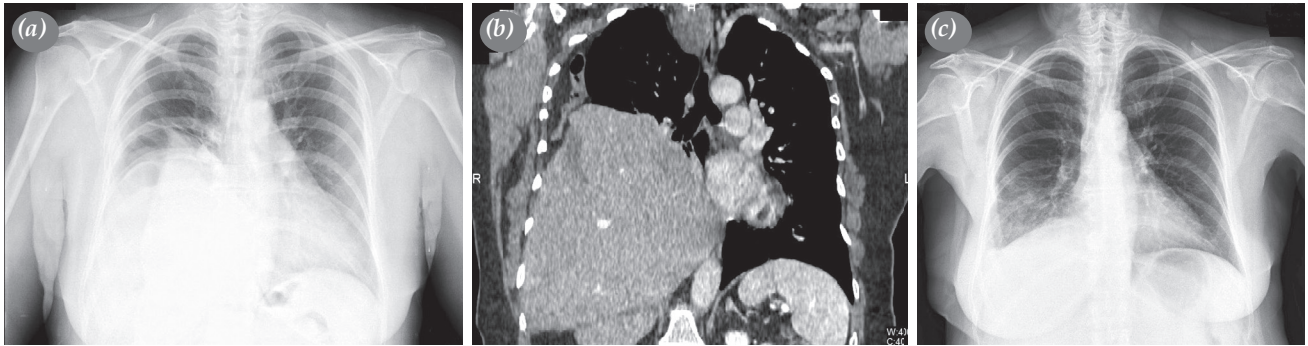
(a) Preoperative chest radiograph, (b) coronal computed tomography image showing herniated intraabdominal organs; liver, colon, omentum, (c) postoperative chest radiograph.
